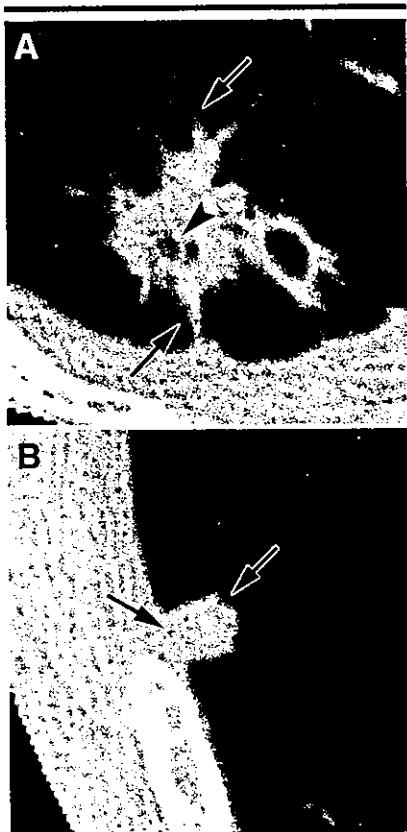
Transverse thin-section CT images. A, Image shows a malignant nodule (squamous cell carcinoma) with air components (arrowhead) and an irregular margin and gross spiculation (arrows). B, Image shows a small benign solid nodule (stable for more than 2 years) with a polygonal shape (arrows) and somewhat smooth margin.
